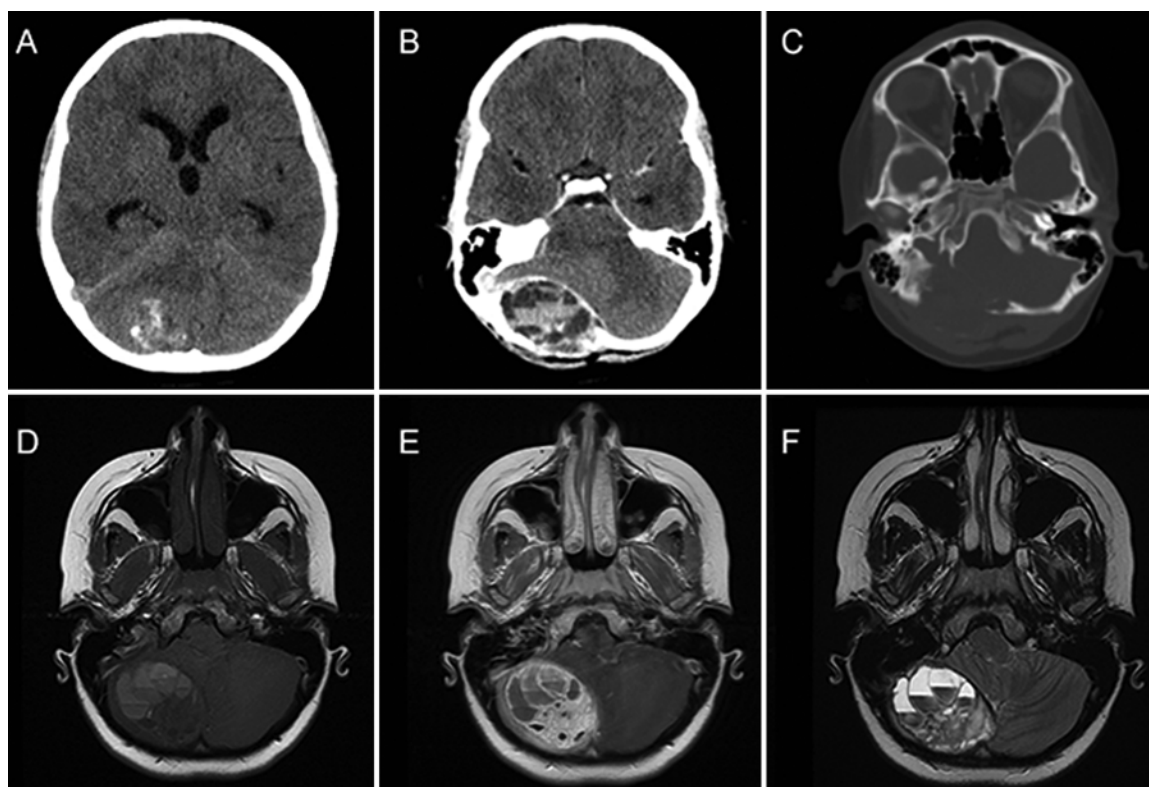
Axial preoperative imaging. A: Unenhanced head CT demonstrating a mass with internal hyperdensity in the posterior fossa compressing the cerebellum, effacing the fourth ventricle, and causing obstructive hydrocephalus. B: Enhanced CT confirms a solid cystic lesion with fluid-fluid levels. C: A bone window on unenhanced CT confirms that the lesion is centered in the occipital bone. D: An unenhanced T1-weighted image demonstrates fluid-fluid levels suggesting a lesion with multiple cysts containing blood products of varying ages. E: A contrast-enhanced T1-weighted image confirms avid enhancing soft tissue surrounding the cysts. F: A T2-weighted image again confirms a lesion with fluid-fluid levels centered in the occipital bone.
